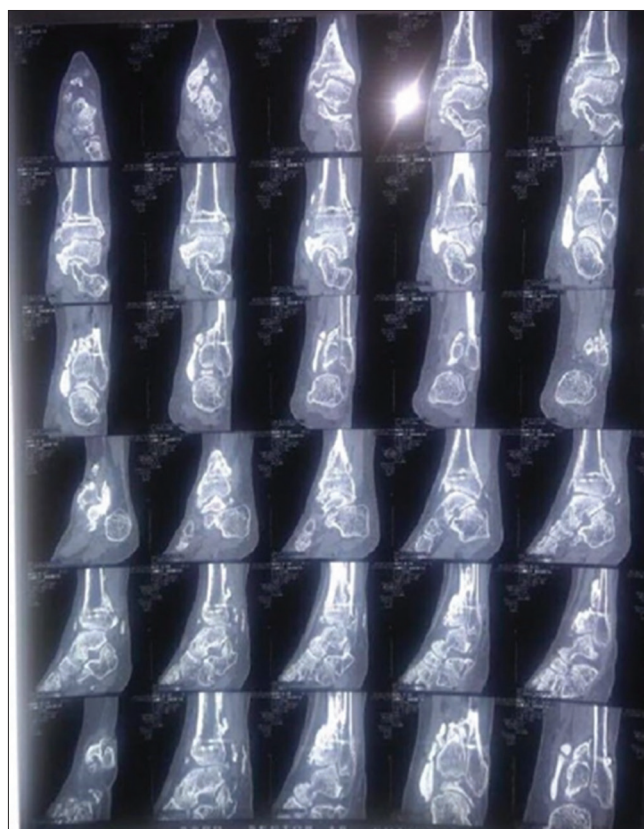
Pre-operative CT scan of the ankle joint with coronal and sagittal reconstruction: There is evidence of old fracture of the metaphysial portion of the tibia with a metallic implant in CT. There is reduction of the tibiotalar joint space with osteophytosis afflicting the tibiotalar joint. There is evidence of new bone formation in the posteromedial aspect of the tibia adjacent to the medial malleolus extending inferiorly up to the calcaneum. There is a slight irregularity of the articular surface of the talus
